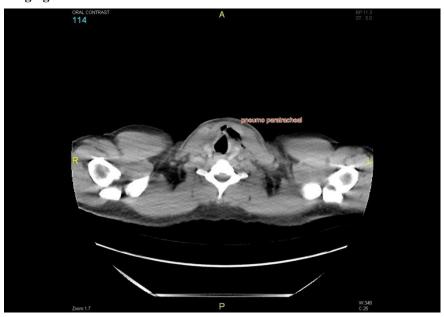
Axial CT Neck: Pneumothroachea. Diffuse stranding and smudging of the mediastinal fat planes with multiple small gas foci noted in the posterior and right para-tracheal regions
